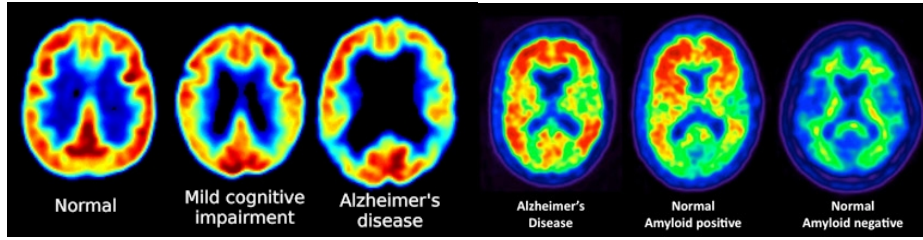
FDG-PET images showing reduced glucose metabolism in temporal and parietal regions in patients with MCI and Alzheimer’s disease (left) . PET scans revealing amyloid plaques, (warm colours, ie. red and orange)(right). Person with no symptoms of cognitive problems, but with evident levels of amyloid plaque in the brain (middle scan) (Baker, 2010).
